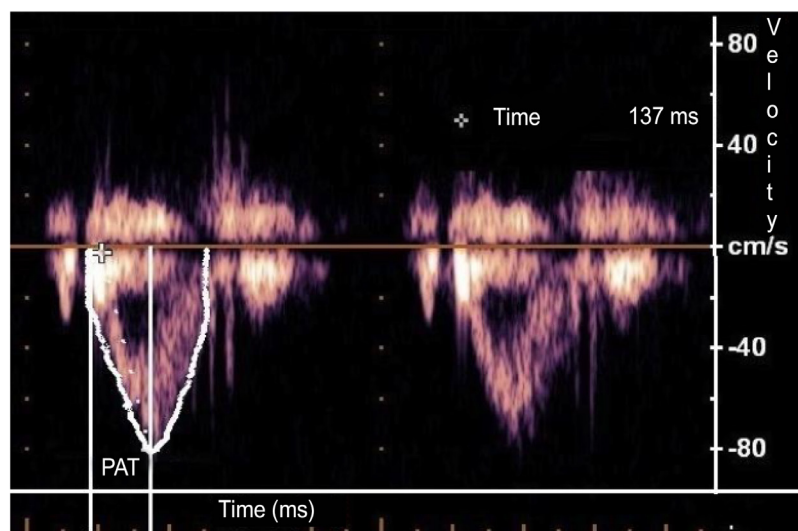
Pulsed-wave Doppler of pulmonary artery (PAT: pulmonary acceleration time = interval from onset of pulmonary flow to peak velocity; shorter acceleration time = higher pulmonary arterial pressure)
